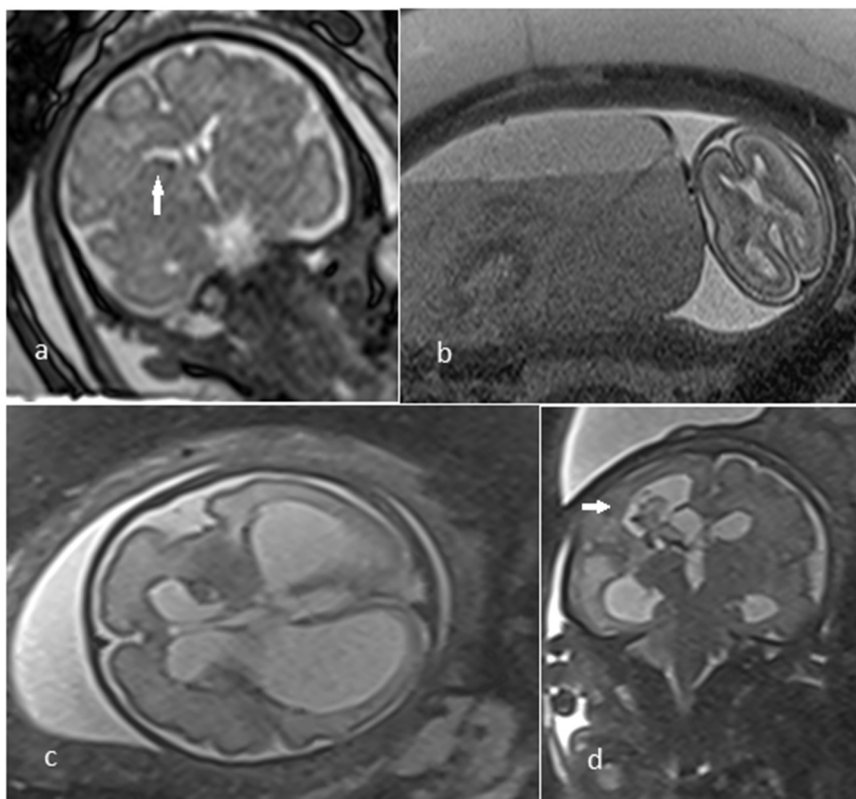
4 different fetuses with IVH grade 1–4 based on Paplie criteria in fetal MRI T2- weighted sequence. a) Unilateral IVH grade 1 in a 35 weeks fetus; b) Bilateral IVH grade 2 in a 20 weeks fetus with placental abruption; c) Bilateral IVH grade 3 with severe ventriculomegaly in a 27 weeks fetus; d) Unilateral IVH grade 4 in a 33 weeks fetus.
